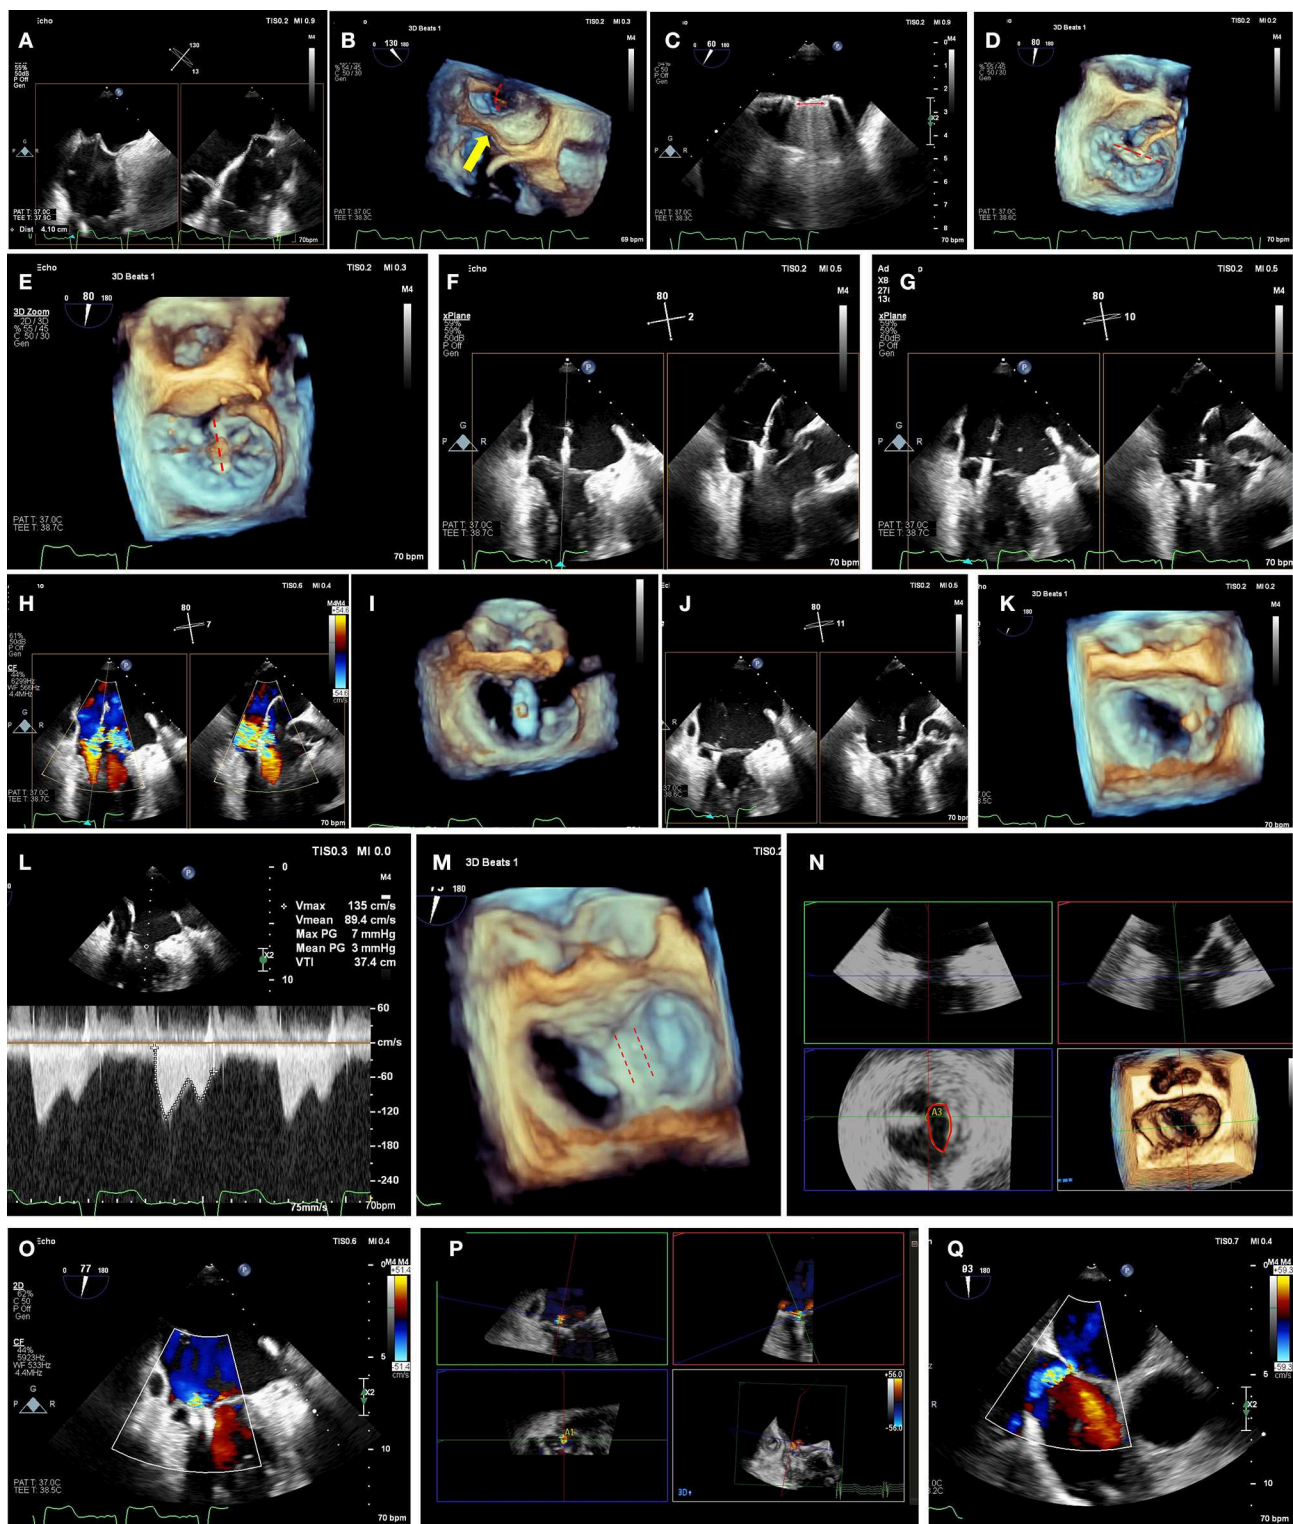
Mitraclip intra-procedural guidance. (A) Transseptal puncture should be performed in a mid-posterior location within the inter-atrial septum, 4.0–4.5 cm basal to the mitral annulus plane. Bi-plane imaging allows simultaneous visualization of the bicaval (typically 90–110°) and the 4-chamber (typically 0 or 180°, or orthogonal view from biplane imaging of bicaval view) view for localization of the puncture. (B) 3-dimensional echocardiographic imaging of needle tenting at the interatrial septum (yellow arrow) confirms trajectory across the mitral commissures (red dashed arch). (C) Extrusion of the mitraclip from the delivery sheath should be
